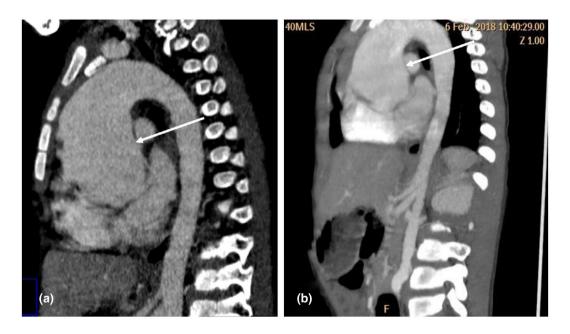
Computed tomography scan of chest showing substantial aortic root dilatation (white arrows), (a) pre-contrast administration; (b) post-contrast administration
